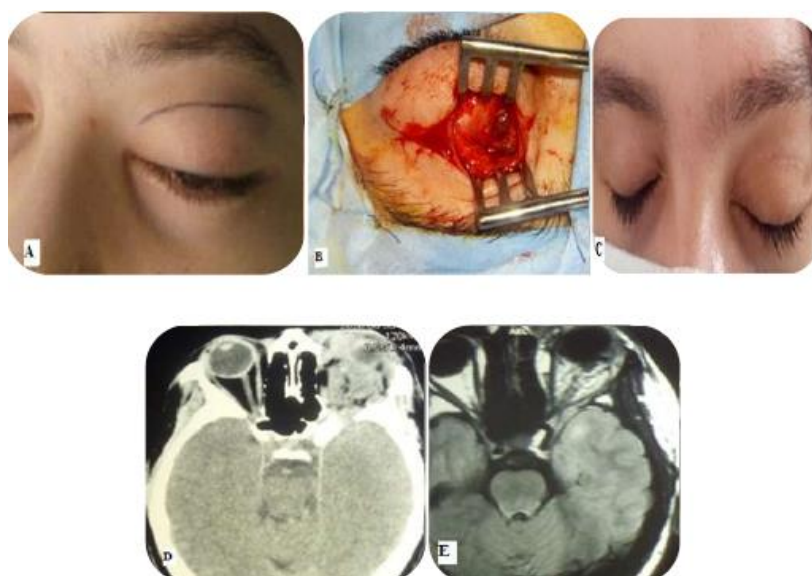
photos of surgery of a multicystic lymphangioma. A: photo of the incision line B: photos of a preoperative aspect of a cyst composing the superior trans-palpebral lymphangioma, C: aesthetic result of skin closure, D: control brain CT and E :Control brain MRI in T2 axial slice showing a reduction of the tumor volume.
